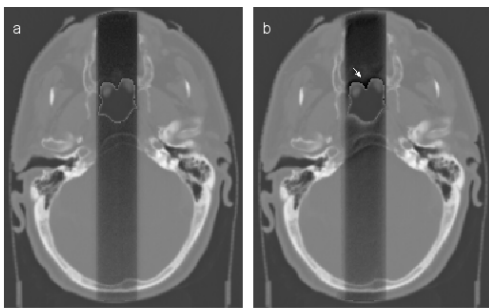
Qualitative image of ERE around the oropharynx. Dose distribution is overlaid on CT-image for $B=0$ (a) and $B=1.5\text{ T}$ (b). Arrow indicates ERE.
